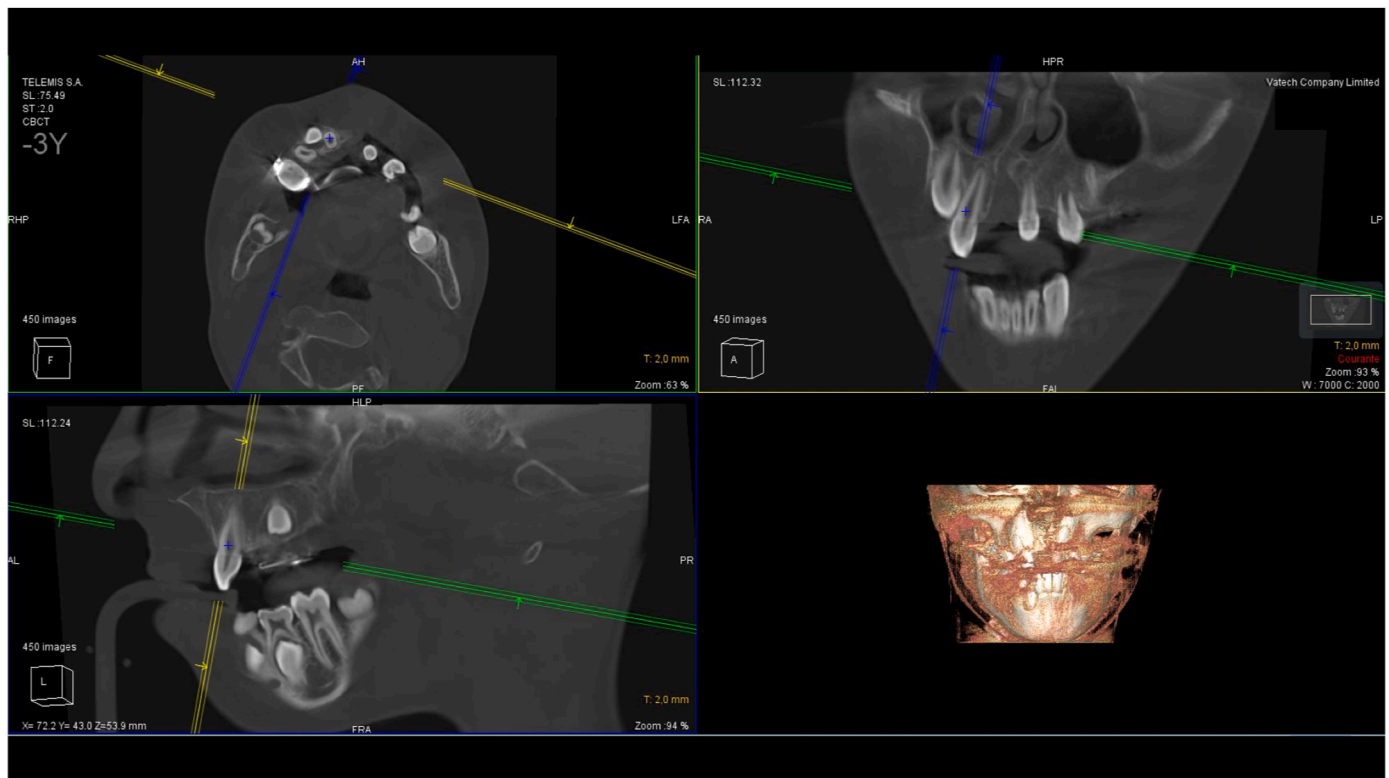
Positioning of 2-mm-thick CBCT slices in vertical and horizontal dimensions.
